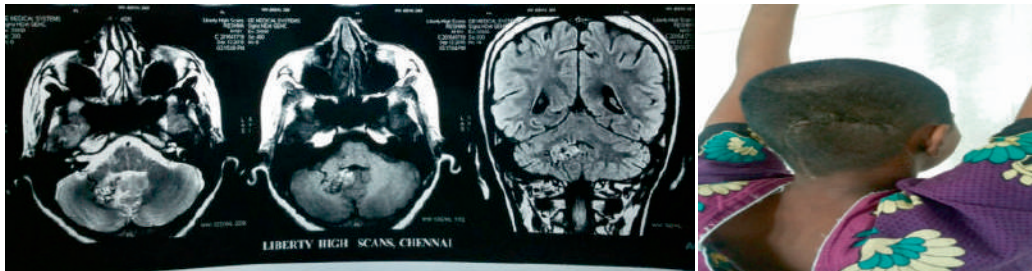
& 4B: MRI brain showing right cerebellar AVM and Post op clinical picture
